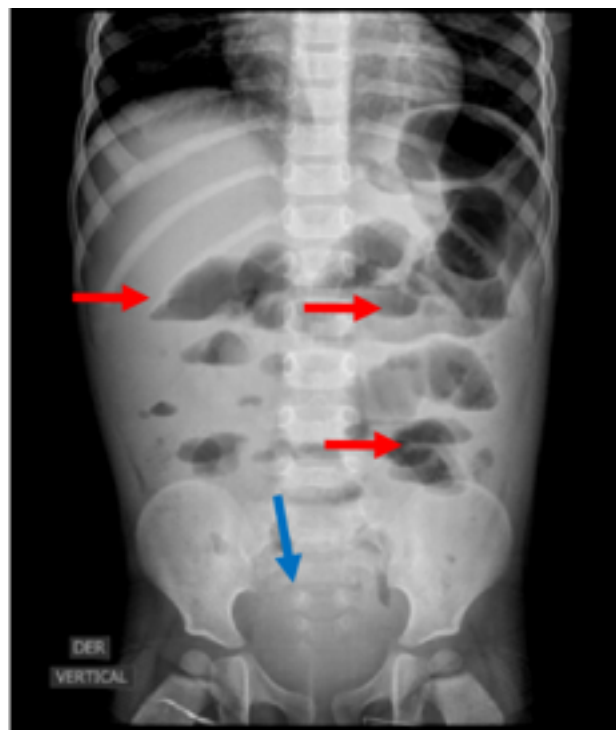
Plain abdominal x-ray (red arrows). Absence of distal gas (blue arrow); air-fluid levels (red levels).
